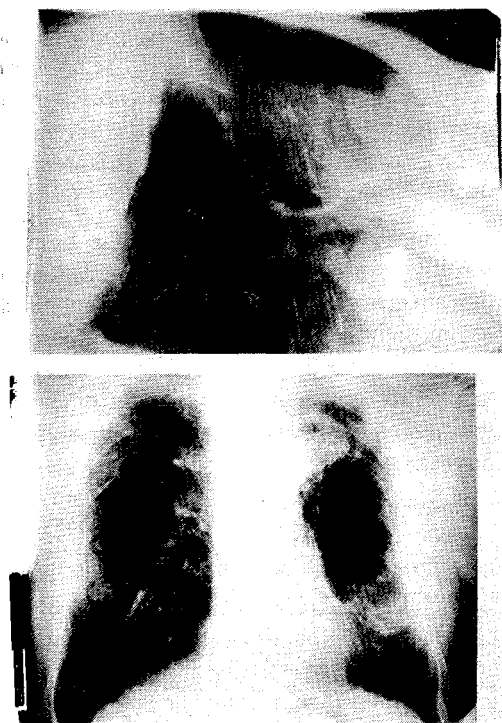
Chest x-rays of September 1991.
